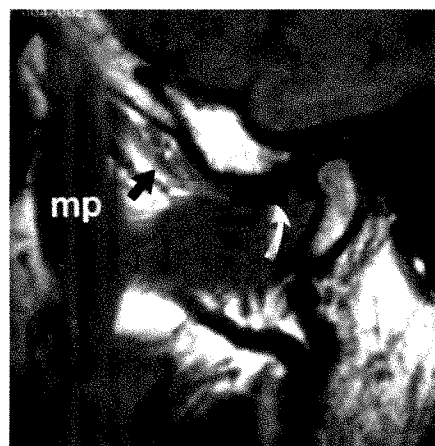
Atrophy, fibrosis, and contracture of superior belly of right lateral pterygoid associated with chronic displacement of TMJ meniscus. Sagittal, closed-mouth TMJ MR image, 600/20, reveals atrophy and fibrosis of superior belly of right lateral pterygoid (*straight arrow*) with anterior displacement, thickening, and deformity of TMJ meniscus (*curved arrow*). Adjacent medial pterygoid (mp) muscle is normal.
